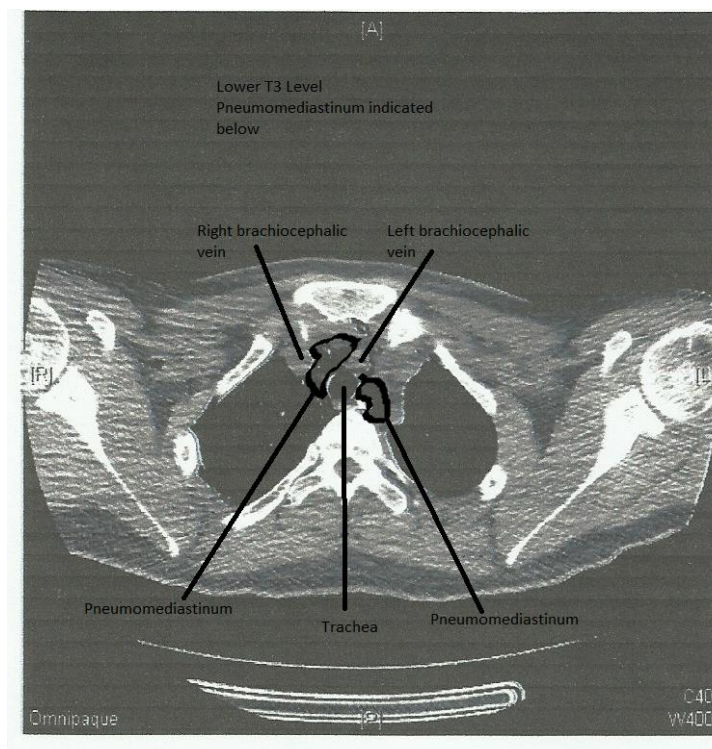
T3 level CT scan
